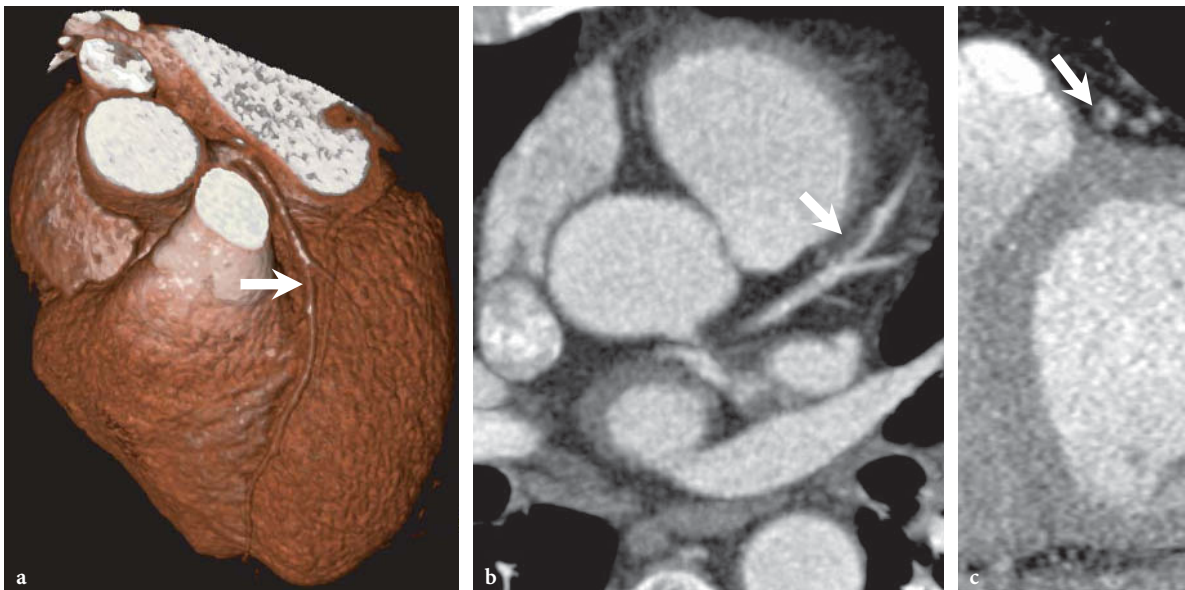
The 64-slice coronary CTA investigation of a patient with unstable angina without signs of myocardial ischemia. a Volume rendering of the dataset shows a regular vessel lumen. b The axial slice, however, demonstrates a well-defined plaque in the middle segment of the left anterior descending coronary artery (*arrow*). c Perpendicular reformatting demonstrates a vulnerable plaque with a low-density (fatty) center surrounded by higher-density (fibrous) tissue. Three weeks later, this plaque ruptured, resulting in an anterior wall infarction in this patient
